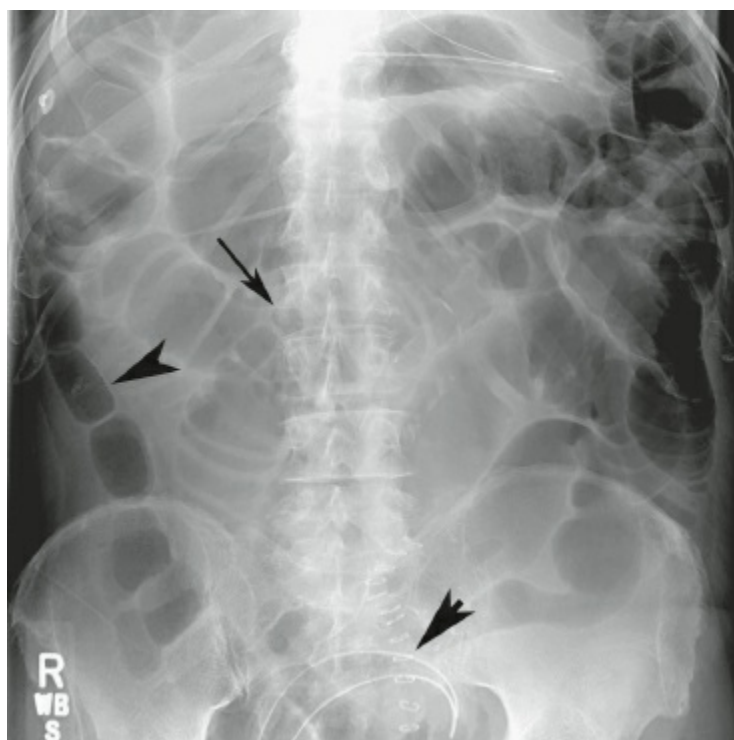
Plain supine abdominal radiograph of a patient with ileus. Air–fluid levels are present in the small intestine (*thin arrow*). Gas is seen in the colon (*thick arrowhead*). These findings are characteristic of, but not specific for, ileus. Surgical drains in the pelvis and skin staples (*short arrow*).
